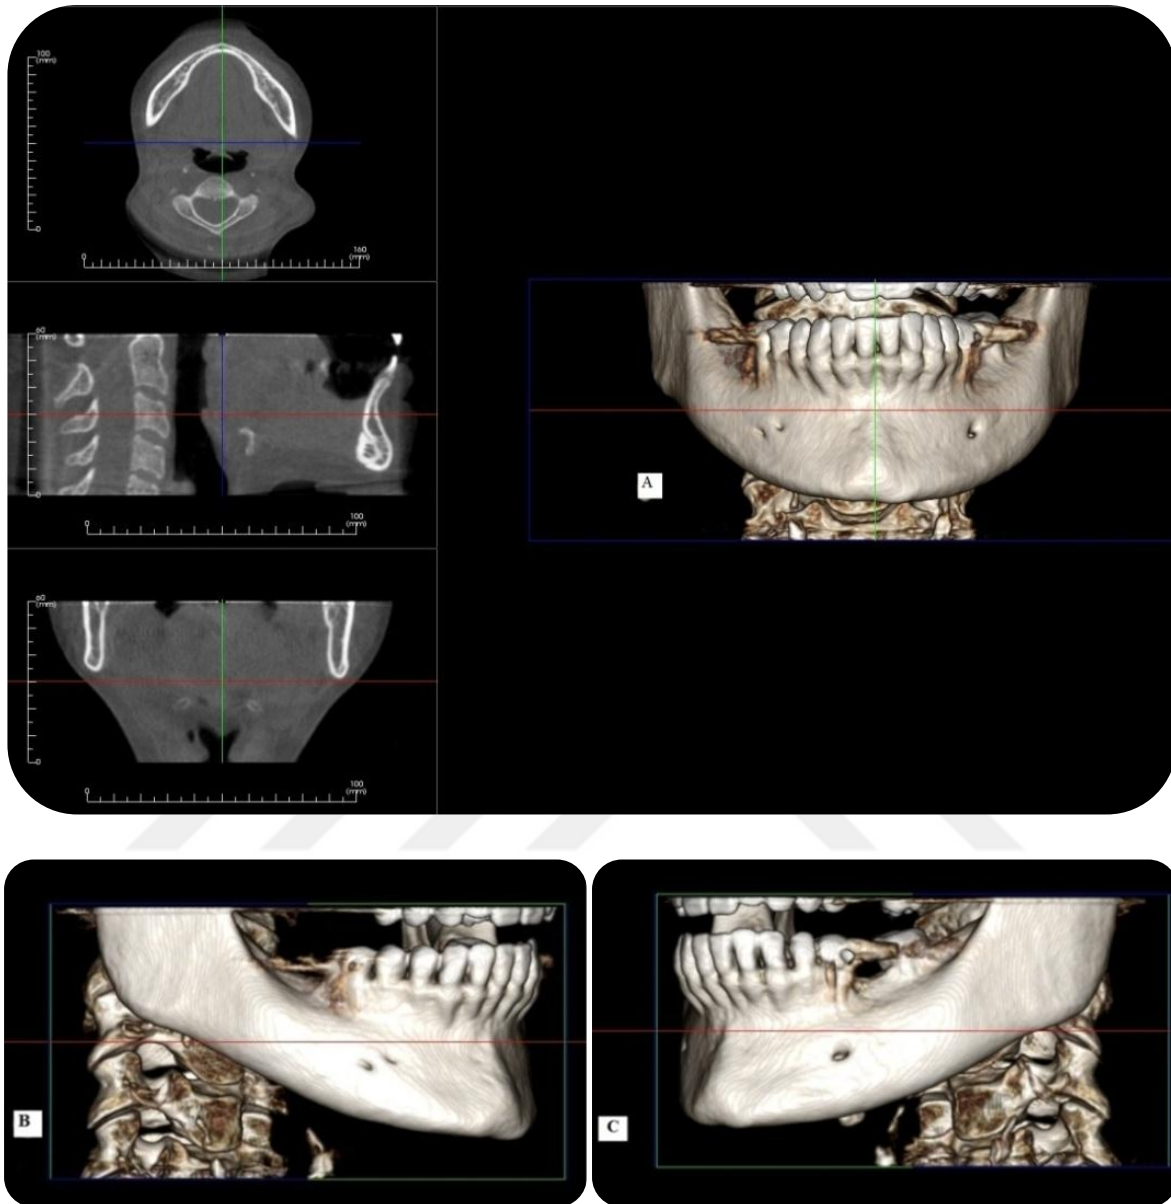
The reconstructed 3-D format in Superimposition option to detect Mental Canal Number (MeCN), showing 2 Mental Foramina on the right side: A: Front view, B: cropped Right 3/4 view and C: cropped Left 3/4 view (Images obtained with i-CAT® Model 17-19; CBCT Imaging Unit: InVivoDental5 Version 5.2 Anatomage, software): Dentomaxillofacial Radiology Department; Faculty of Dentistry- University of Yeditepe.
